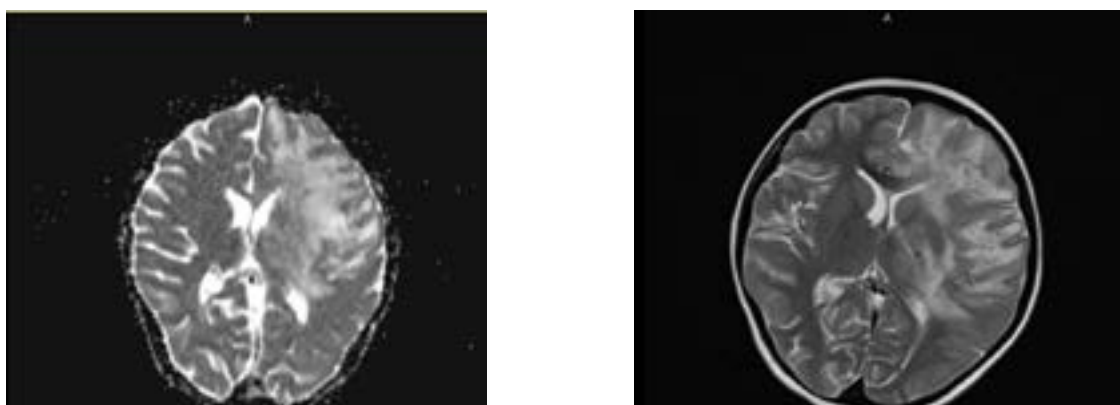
Brain MRI and DWI
